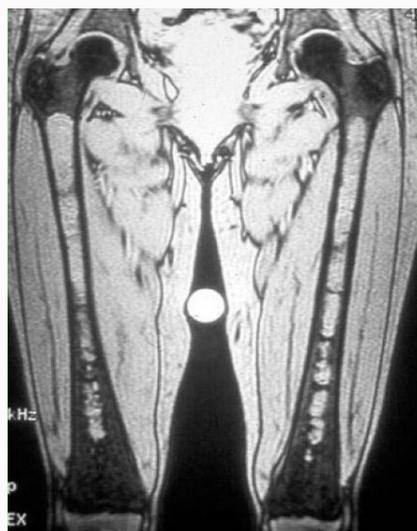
Case 1: Femurs MRI demonstrating bone marrow infiltration with a "Salt and Pepper" appearance.
